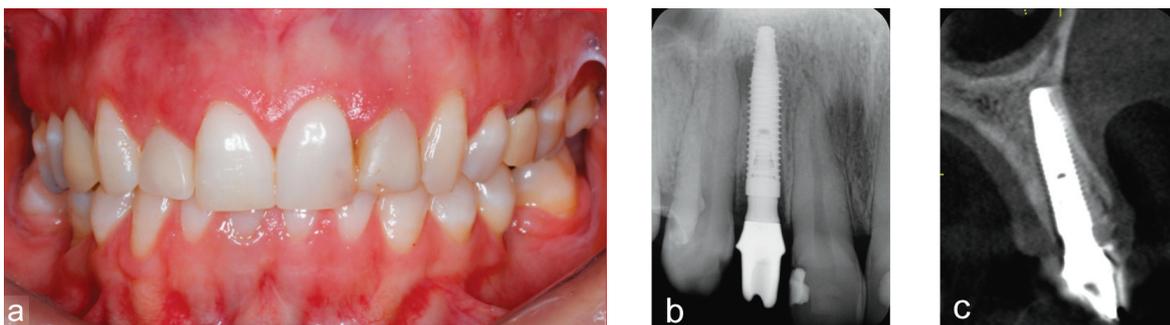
Immediate postoperative phase: temporary crown installed immediately upon implant placement (a); immediate periapical radiograph (b); immediate CBCT (c).
